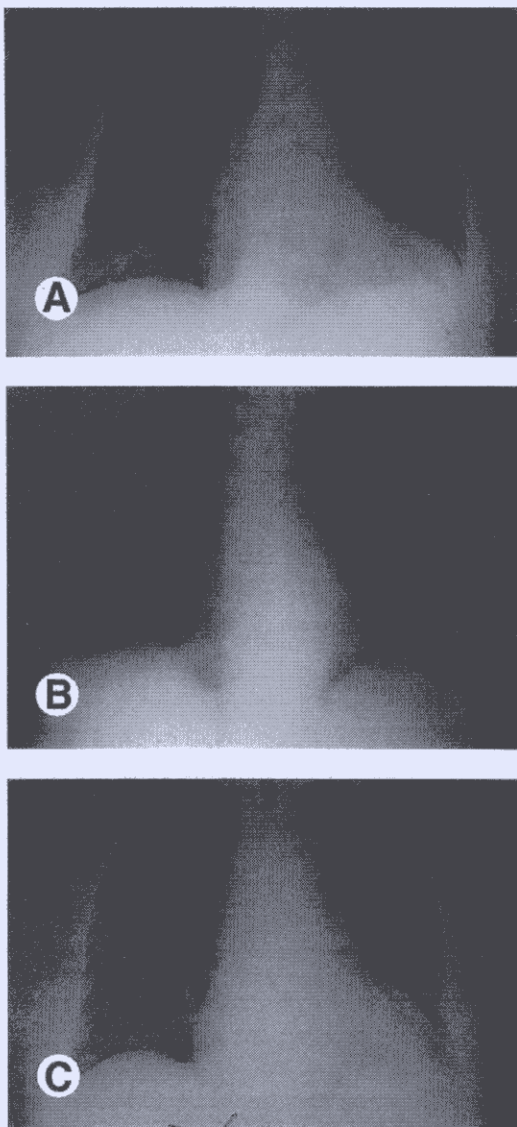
Serial chest radiographs of patient 4, who presented with fever and cough. (A) Ill-defined air-space opacities over bilateral lower zones on day 1 of presentation. (B) Apparent resolution of initial presenting lung opacities on day 3. (C) Subsequent reappearance of bilateral lower zones opacities.
